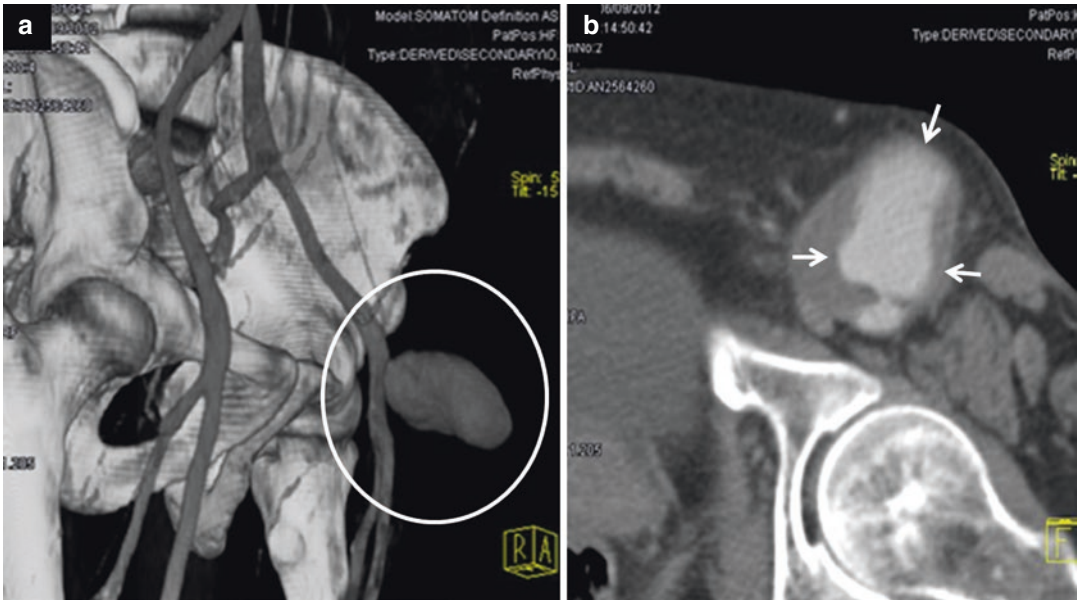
TEVAR, access site complications. (a) Volume-rendered (3D-VR) image and (b) axial CT scan show large pseudoaneurysm of left common femoral artery (*white circle in a and white arrows in b*)
